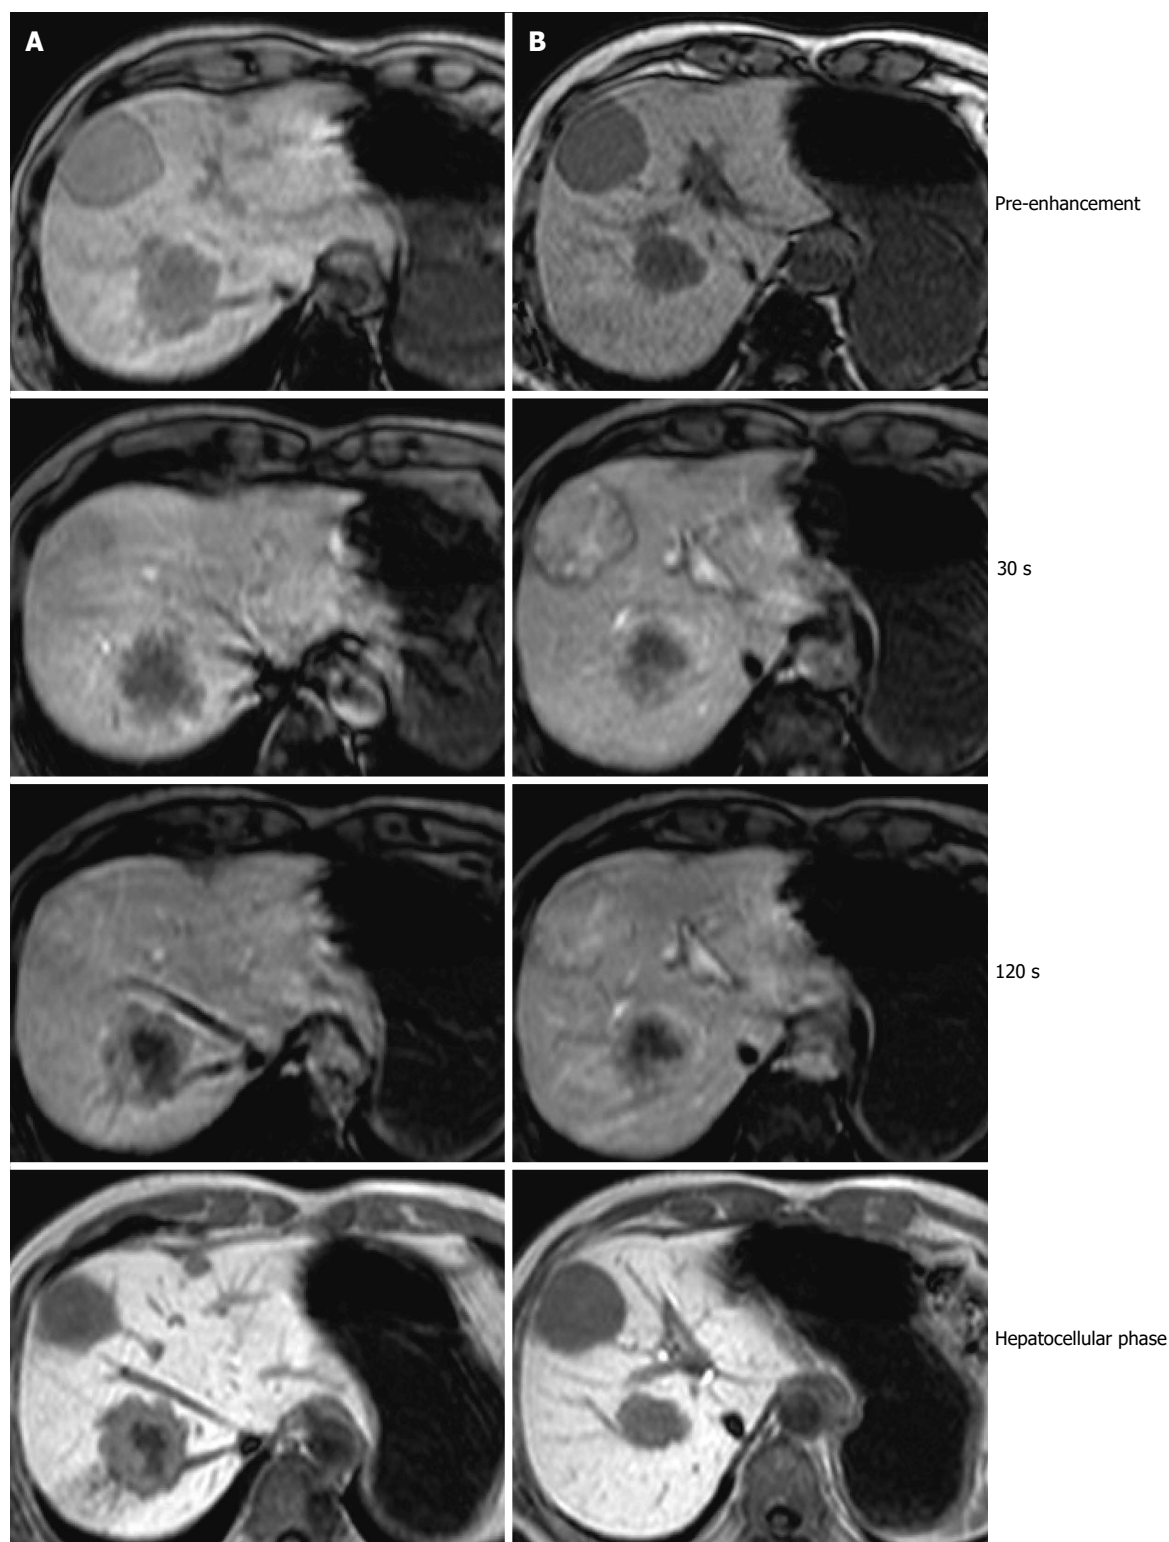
Ethoxibenzyl-magnetic resonance imaging before treatment. The tumors in Segments 3 and 8 showed gradual peripheral enhancement, while the tumor in Segment 4 showed heterogeneous enhancement and washout characteristics. A: S3 and S8 gradual peripheral enhancement; B: S4 heterogeneous enhancement.
